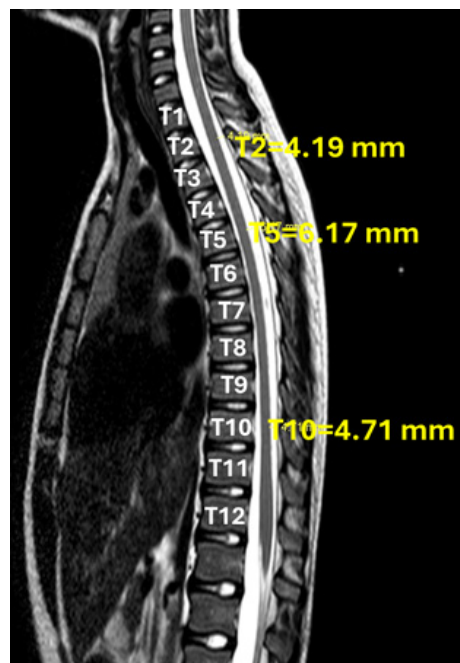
Distance between dura mater and spinal cord with MRI.
